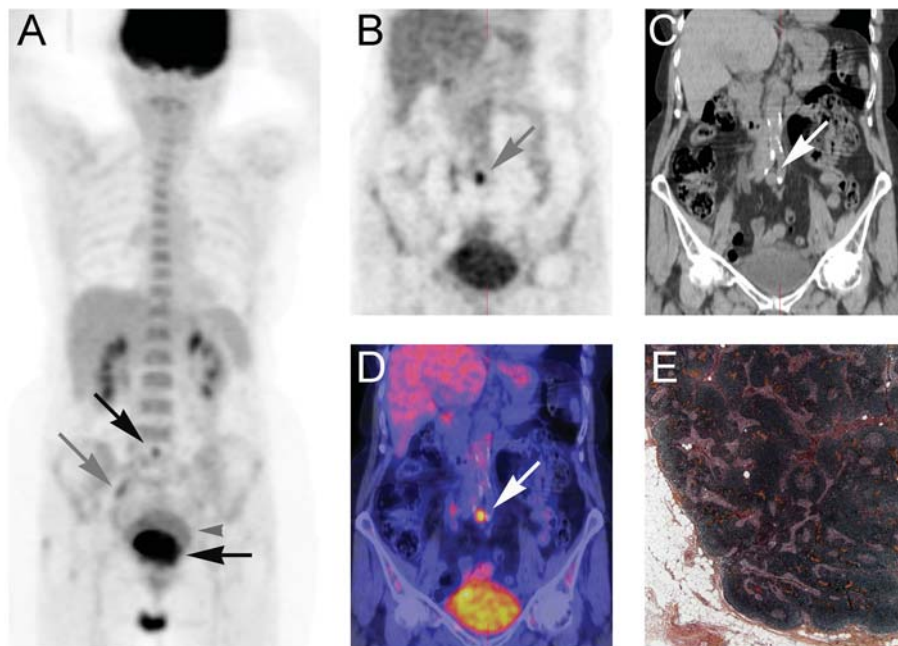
Inflammatory paraaortic lymph node of cervical squamous cell carcinoma, FIGO stage IVA. Cervical cancer (horizontal black arrow) with right pelvic lymph node (grey arrow) and paraaortic lymph node (PALN) uptake (black arrow) shown on anterior maximum intensity projection (MIP) view of FDG-PET (A). Note that urine was diluted in bladder (grey head arrow) after diuretic injection (A). PALN (arrow) was detected on FDG (B), on CT (C) and in fused data (D) coronal slices. Finally, PALN was inflammatory on pathological HES examination  $\times 25$  (E).
